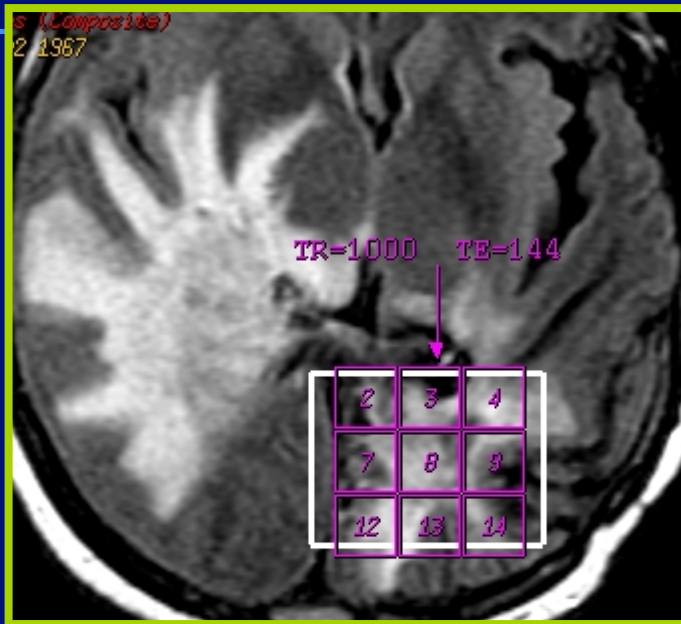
A 67-year-old patient with astrocytoma grade II. MR examination 36 months after stereotactic radiotherapy showed two contrast-enhancing lesions on T1-weighted spin-echo images.
